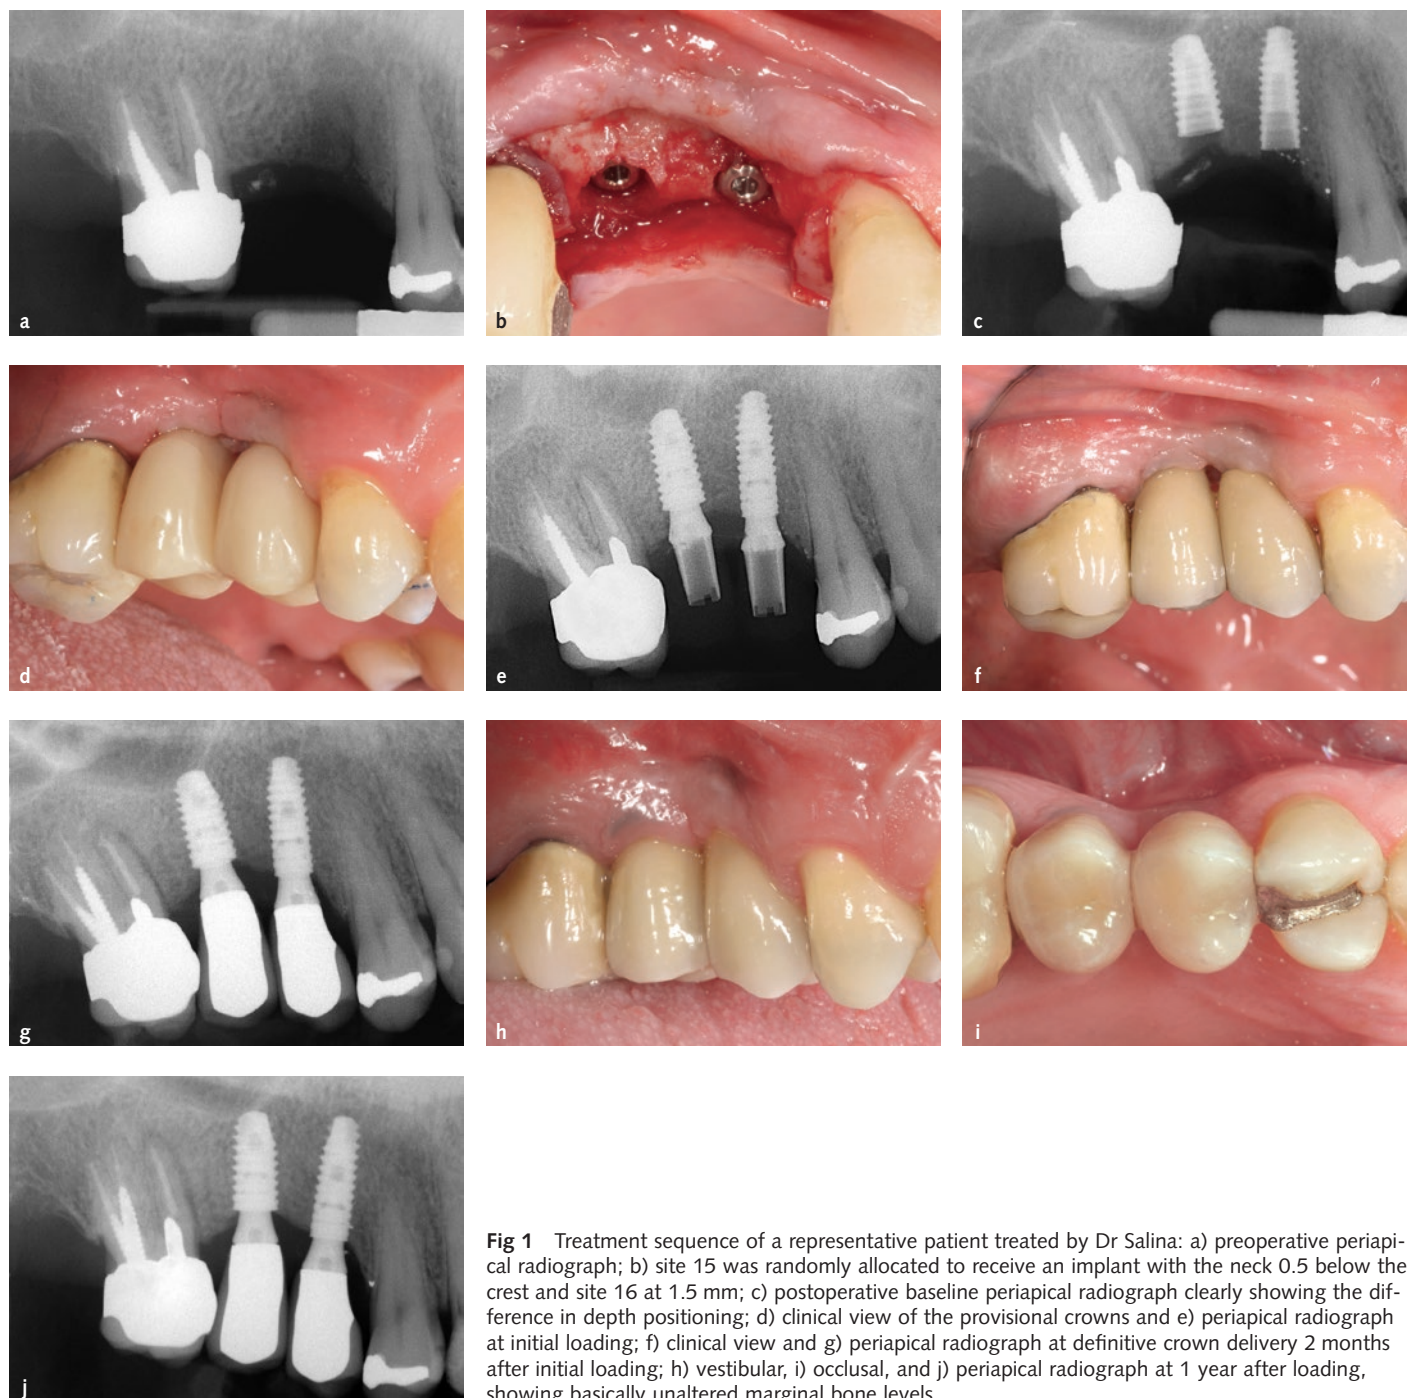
Treatment sequence of a representative patient treated by Dr Salina: a) preoperative periapical radiograph; b) site 15 was randomly allocated to receive an implant with the neck 0.5 below the crest and site 16 at 1.5 mm; c) postoperative baseline periapical radiograph clearly showing the difference in depth positioning; d) clinical view of the provisional crowns and e) periapical radiograph at initial loading; f) clinical view and g) periapical radiograph at definitive crown delivery 2 months after initial loading; h) vestibular, i) occlusal, and j) periapical radiograph at 1 year after loading, showing basically unaltered marginal bone levels.
